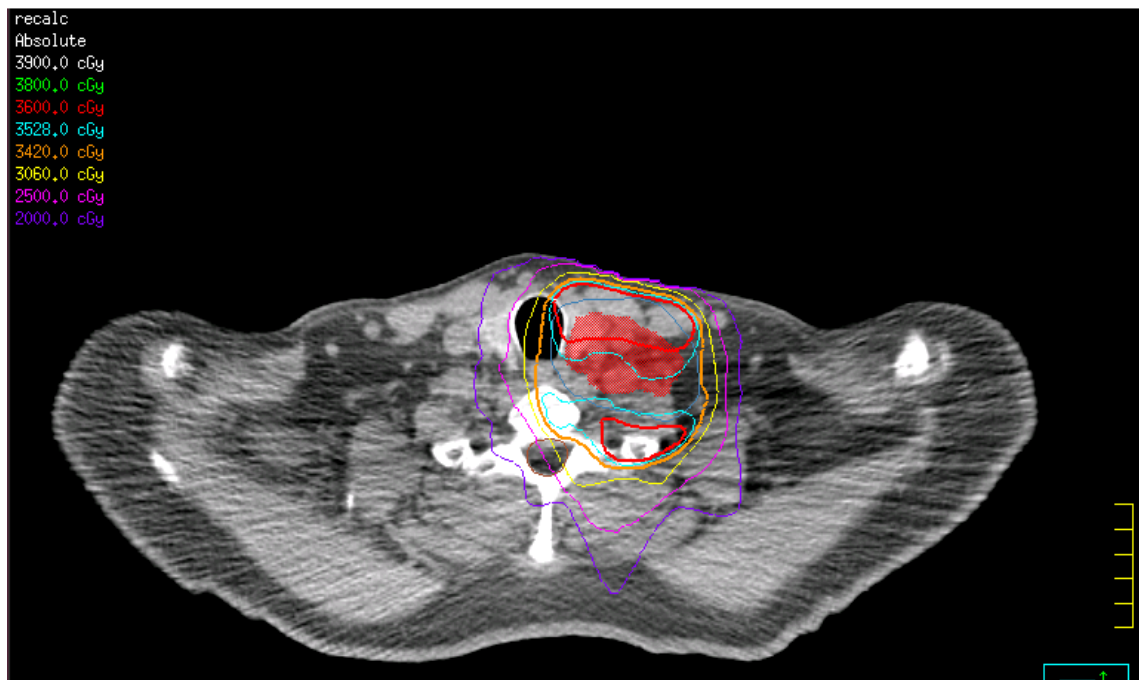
Case 2 daily CT with shoulder shifts. Isodose lines have similar distribution around CTV.
